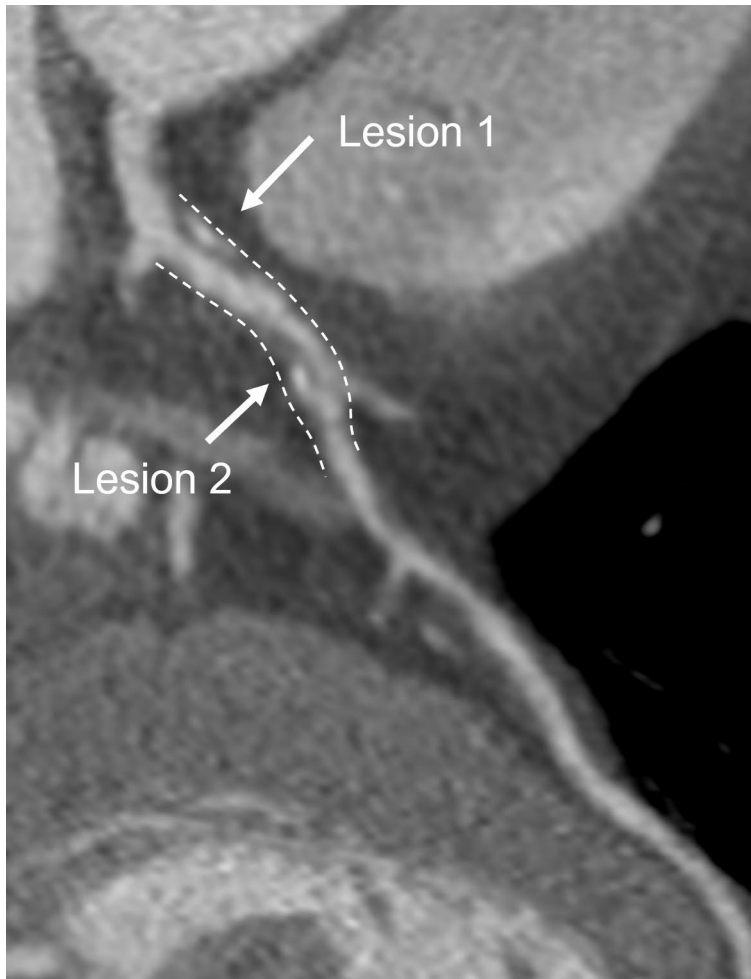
Coronary computed tomography angiography image of proximal left anterior descending artery. In lesion 1 mild stenosis (25–49%) is observed. In lesion 2 there is moderate stenosis (50–69%) with positive remodelling.
